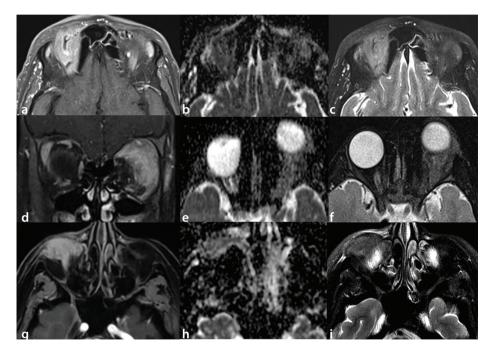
Space-occupying soft tissue masses with diffuse contrast enhancement on post-contrast T1-weighted images were observed in 3 patients diagnosed with primary orbital lymphoma (a), immunoglobulin G4-related orbital disease (lgG4-ROD) (d), and sarcoidosis (g); these lesions demonstrated overlapping apparent diffusion coefficient (ADC) values on ADC maps (b, e, and h, respectively); transverse relaxation time (T2)-weighted images helped differentiate lymphoma (c) from lgG4-ROD and sarcoidosis (f and i, respectively), with lymphoma appearing isointense to the cerebral cortex, whereas the inflammatory mimickers appeared hypointense.
